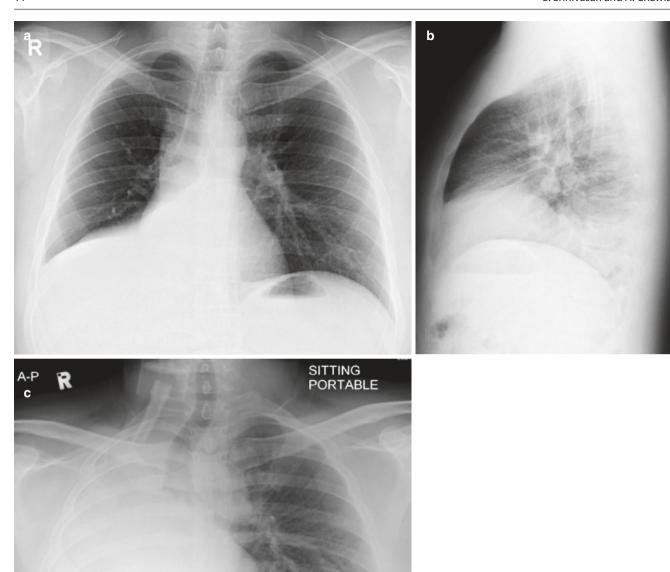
Right lower lobe collapse in a young woman presenting to emergency department with dyspnea. (a, b) Frontal and lateral chest radiographs show signs of the collapse of the right lower lobe. (c) Frontal chest radiograph on the following day shows complete right
